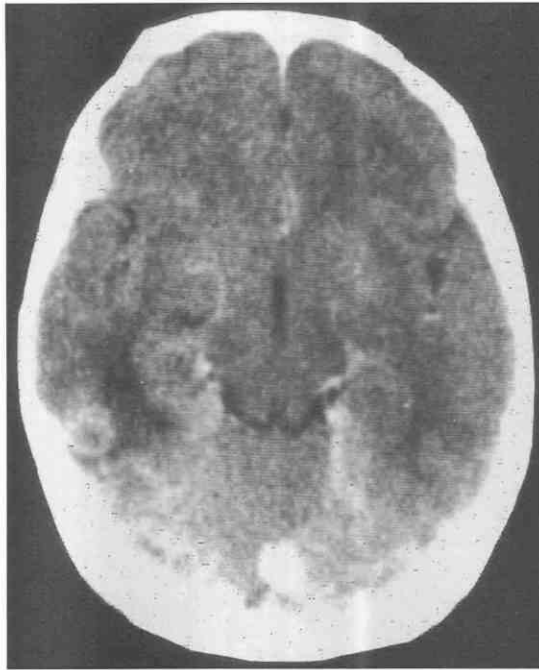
Cryptococcosis. Contrast CT scan shows a ringlike enhancement in the right posterior temporal lobe with surrounding edema.
